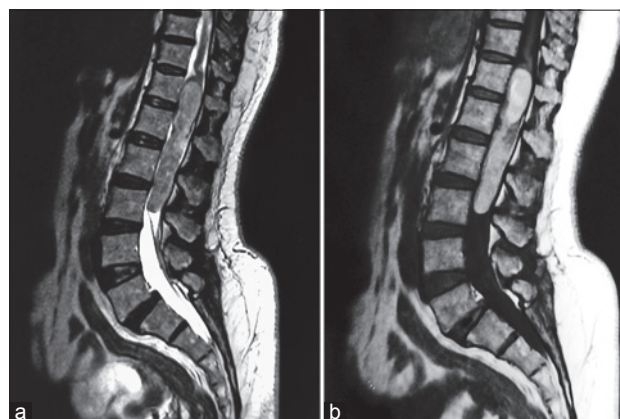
Sagittal T2-weighted (a) and T1-weighted post-gadolinium (b) magnetic resonance images showing a partially cystic and enhancing intradural mass located between T12 and L3 spinal levels
